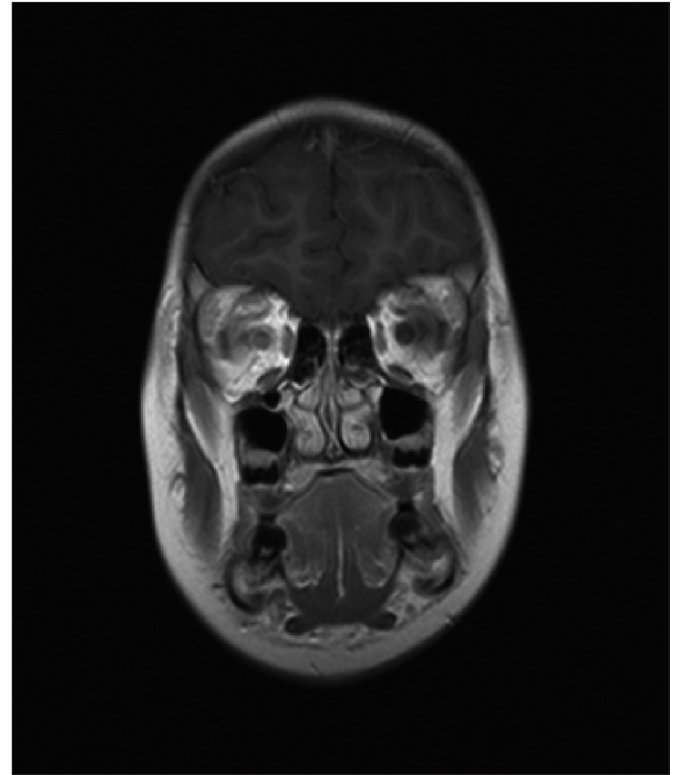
Coronal T1-weighted, gadolinium-enhanced magnetic resonance image demonstrating swelling and enhanced signal in both optic nerves, worse on the right.
